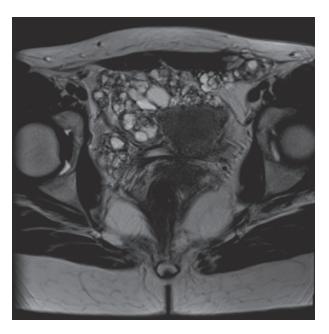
MRI abdomen pelvis, T2 axial image, important pelvic cavity invasion with vesicular like lesions, englobing the uterus, the left iliac region with involvement of the posterior fascia of the left rectus abdominis muscle.
